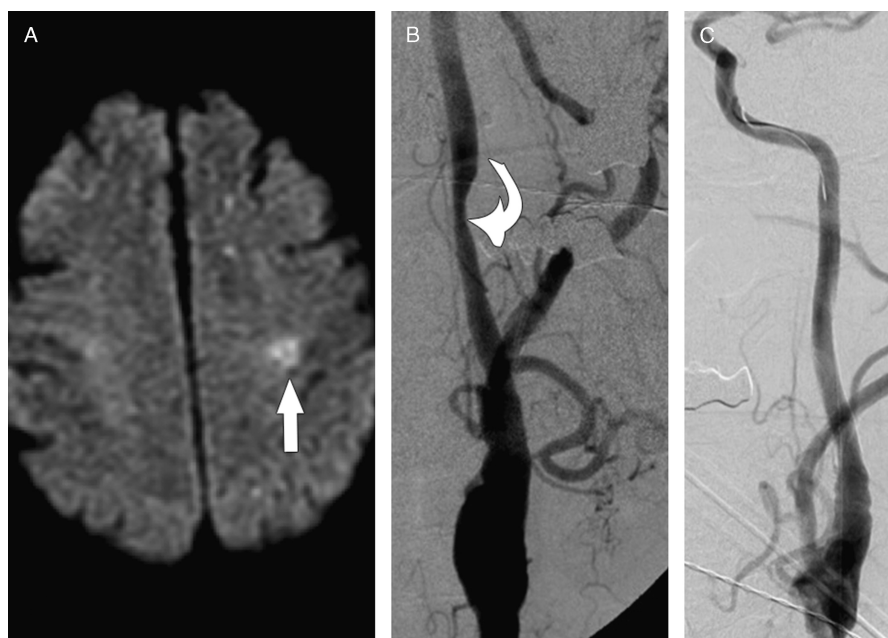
A 45-year-old status post–gunshot trauma to the neck. *A*, Diffusion-weighted magnetic resonance image through the upper cerebrum demonstrates focal diffusion restriction compatible with acute infarction within the posterior left frontal lobe (arrow). *B*, Digital subtraction angiogram upon injection of the left common carotid artery demonstrates focal narrowing of the midcervical left ICA compatible with dissection (curved arrow). *C*, Poststent repair left common carotid injection digital subtraction angiogram demonstrates resolution of dissection related narrowing without evidence of flow restriction within the left ICA.
